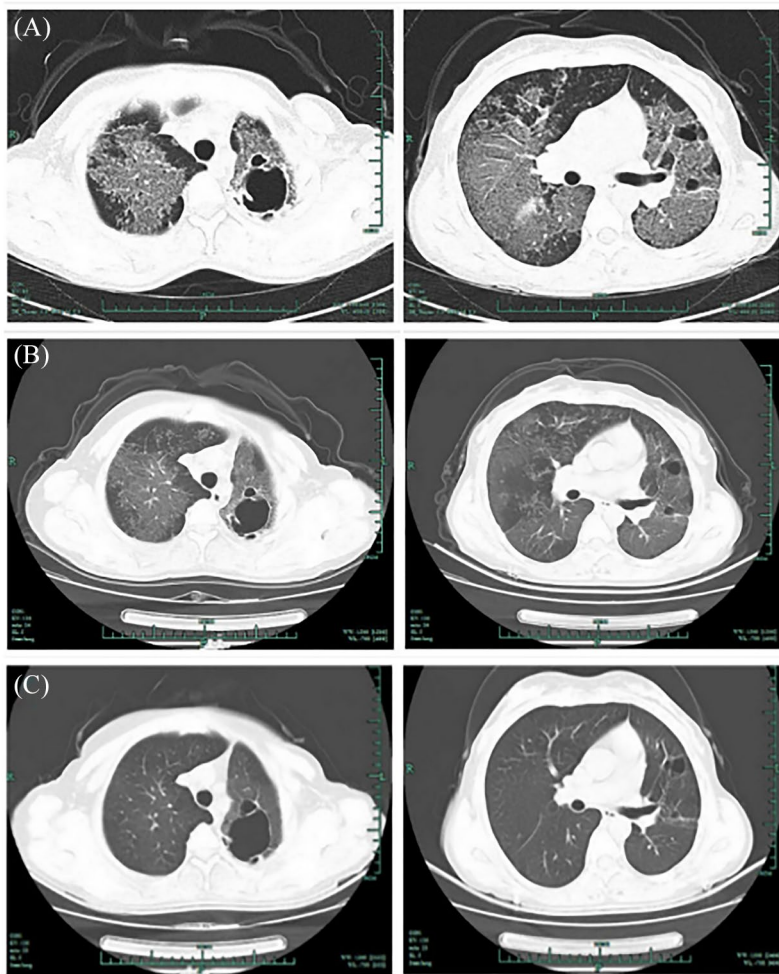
(A) Past chest CT scan (1 January 2019) showing multiple disseminated ground glass opacities with multiple bullae. (B, C) Chest CT scan during follow up (26 January 2019 and 27 April 2019, respectively) showing distinct resolution of both lungs. CT, computed tomography.
